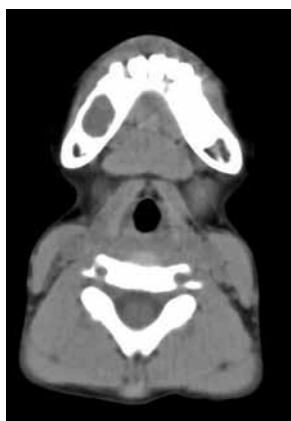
Computed tomography revealed that the dimensions of the radiolucent lesion were approximately 20.2 mm × 22.1 mm, and were not significant in the buccolingual direction.
